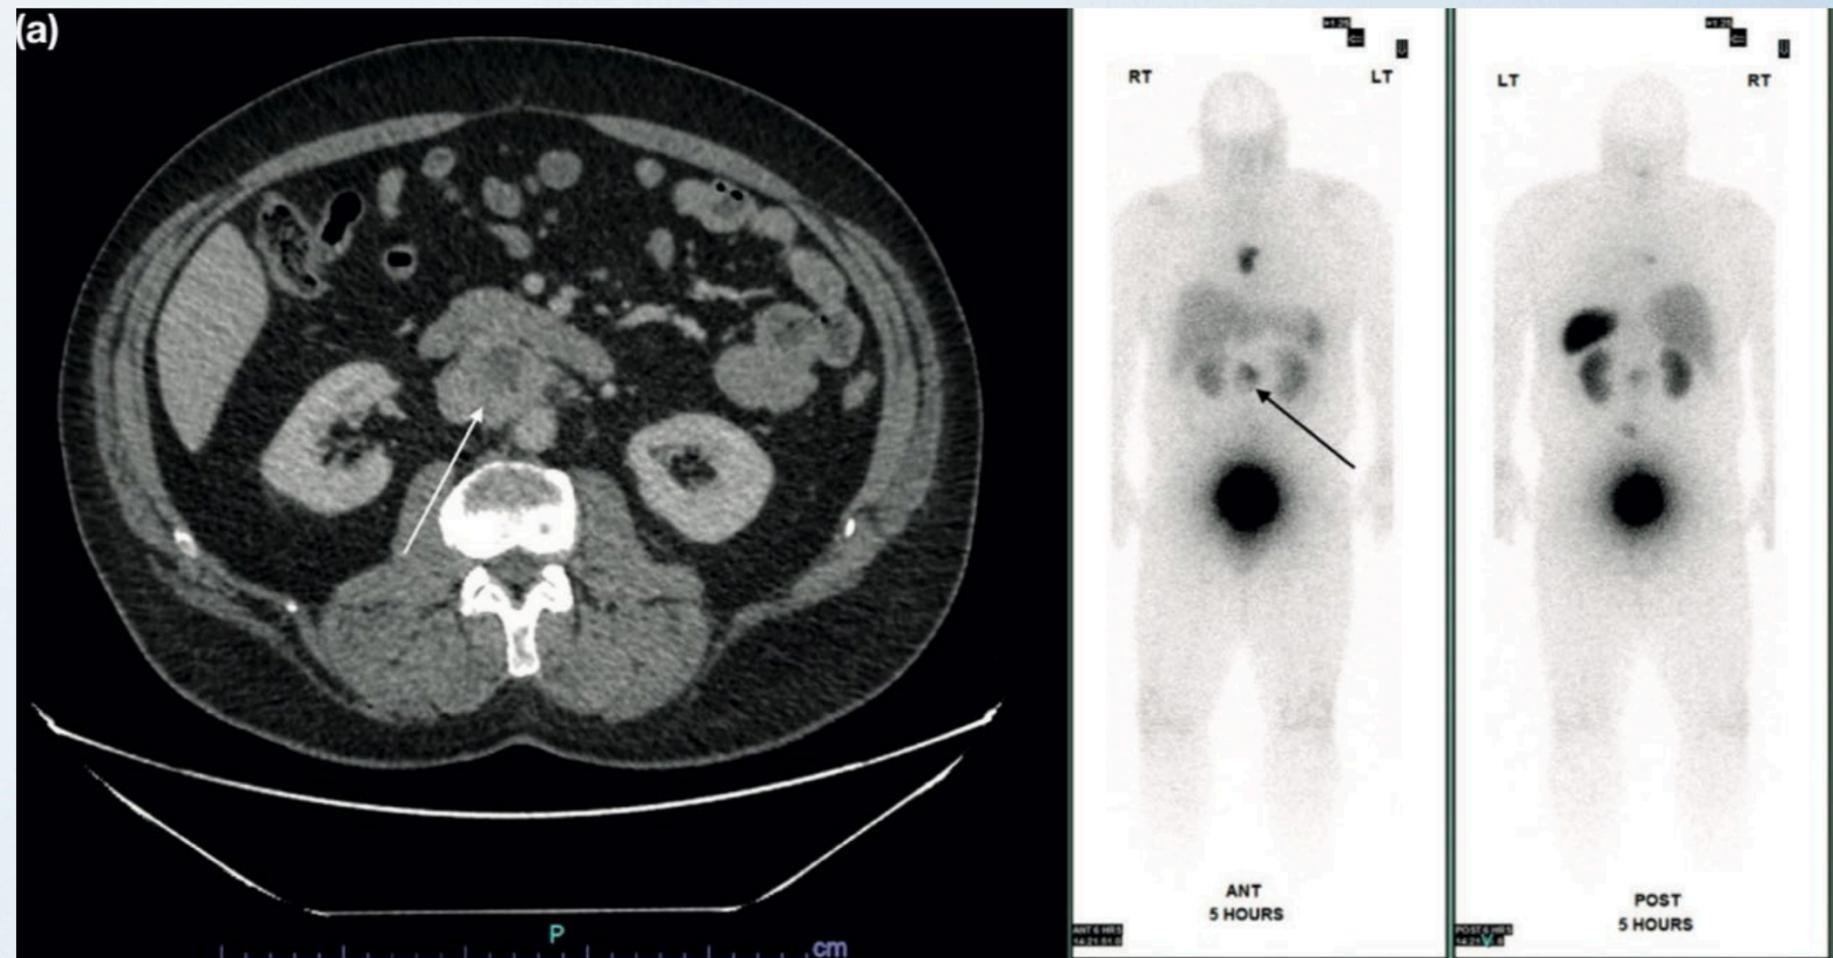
A cross-section computed tomography scan of a large pheochromocytoma showing characteristic central necrosis (arrow).
